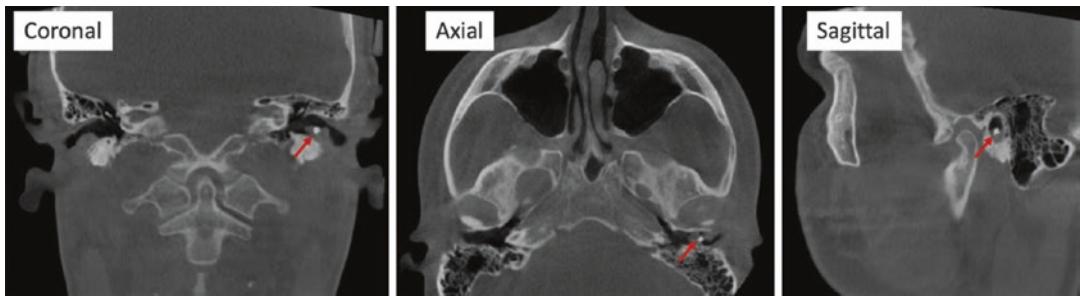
Calcification are noted on CBCT images in ear canal with an opaque foreign object
